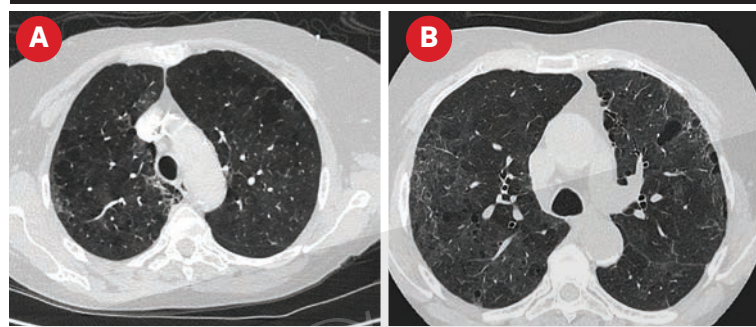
Final CT. Figures 6A, 6B, 6C and 6D. CT with resolution of basal inflammatory changes but persistence paraseptal emphysema.
